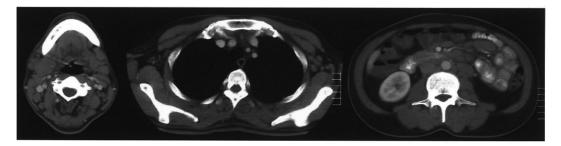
CT scans demonstrated multiple lymphadenopathy including bilateral submandibular, deep cervical, bilateral axillar, paraaortic and mesenteric regions.
